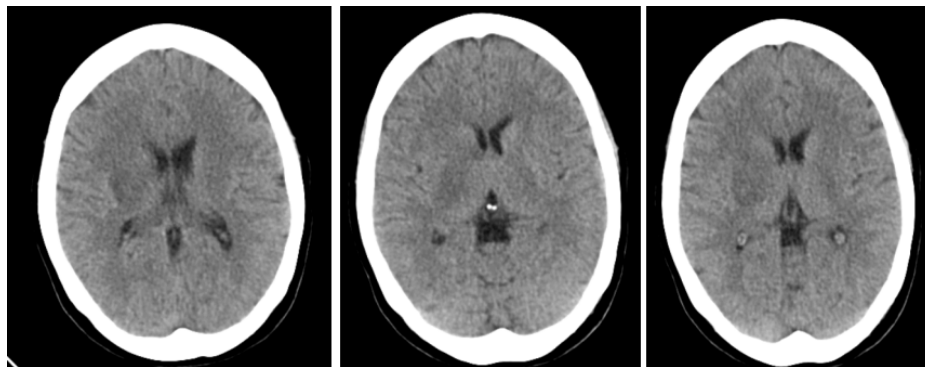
Cranial CT: space occupying lesion on the right hemisphere deforming the ipsilateral ventricle
